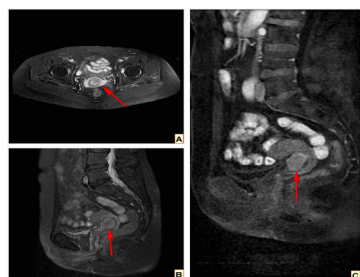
Pelvic MRI Scan revealed that uterine cervical anterior lip volume increase, about 26 mm × 16.1 mm × 16.1 mm, with a clear margin.
